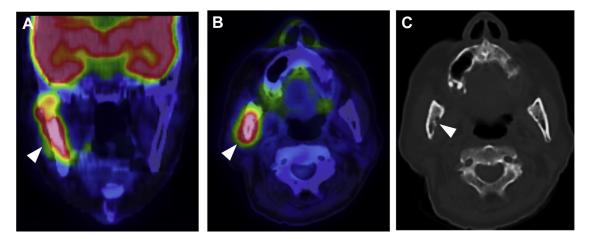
Positron emission tomography and computed tomography findings for an 84-year-old man who presented with hoarseness and cough. Both coronal (*A*) and transverse (*B*) images from the positron emission tomography scan show a fluorodeoxyglucose-avid lesion in the right side of the jaw (*arrowheads*), and the computed tomography scan (*C*) shows an osteolytic lesion (*arrowhead*).
